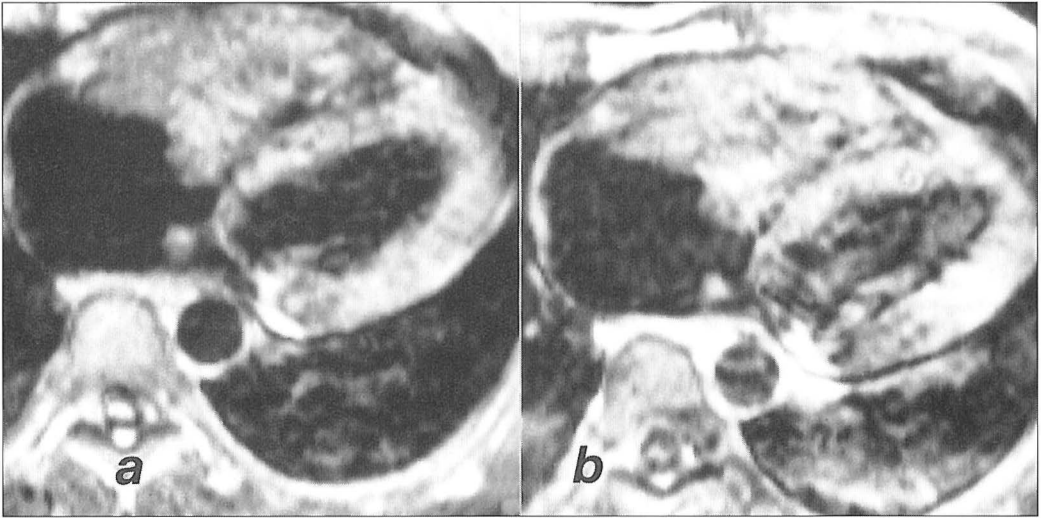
Metastatic seminoma to the right ventricle. T1-weighted axial SE images before (a) and after (b) the administration of Gd-DTPA. The right ventricle is almost completely filled with the tumor-thrombus, that can not be differentiated from the anterior ventricular wall (tumor ingrowth). On operation, anterior wall was invaded and the tumor could not be excised completely.
